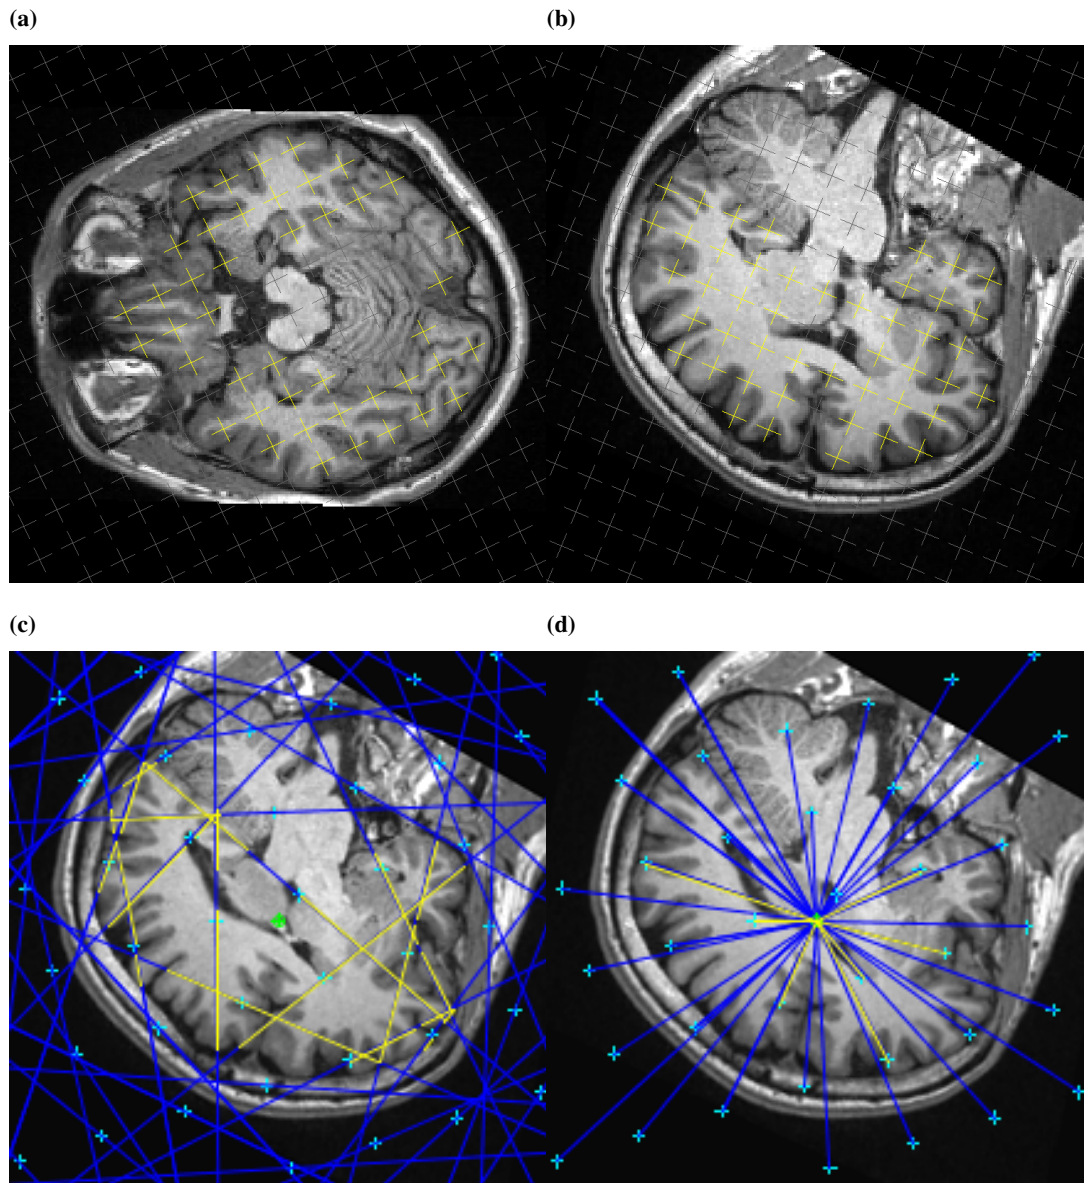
Examples of estimations of cerebral parenchymal volumes on a healthy brain MR image measured by four stereological methods: (a) the CAVALIERI method (yellow points counted on one slice in the transversal view), (b) the ICAV method (yellow points counted on one of IUR parallel slices), (c) the INV method (yellow segments on one IR rotated slice) and (d) the DN method (yellow segments on one IR rotated slice).
